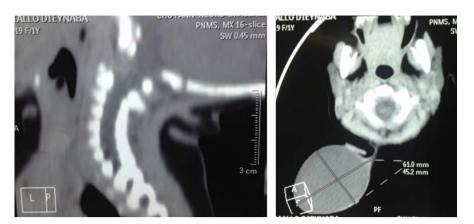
CT scan of the cervical spine showing the cervical meningocele in the form of a cystic mass with subcutaneous expansion arising from the medullary canal from the C1 lamina defect where the very small neck is located.
